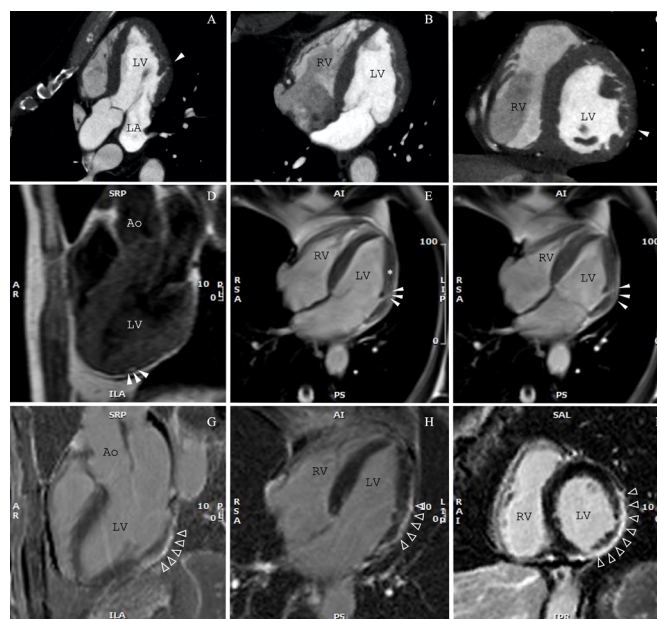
A-C: three-, four- and short axis cardiac views at cardiac CT. There is reduced LV wall thickness at the lateral and infero-lateral wall (arrow-head) with small areas of reduced/negative density within the myocardium, which is in favour of the presence of fat tissue. D – T1-weighted turbo spin Echo sequence at CMR with areas of fat infiltration (arrowheads) on the infero-lateral wall of the LV. E-F – CMR horizontal four-chamber view at cine (SSFP) images with mid-lateral LV wall akinesia (arrowheads) and intramyocardial chemical shift artifact (*), also favouring the presence of fat infiltration. G-I: extensive subepicardial late gadolinium enhancement at three, four-chamber and short-axis CMR views (arrowheads). LV – left ventricle; RV – right ventricle; LA – left atrium; Ao – Aorta; CMR – cardiac magnetic resonance; SSFP – steady-state free precession.
